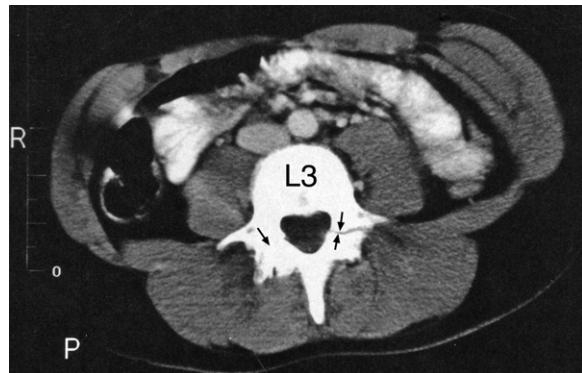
CT abdominal image. Note what appears to be a fracture of the left L3 pars interarticularis (short arrows) with a possible fracture on the right side (long arrow).
